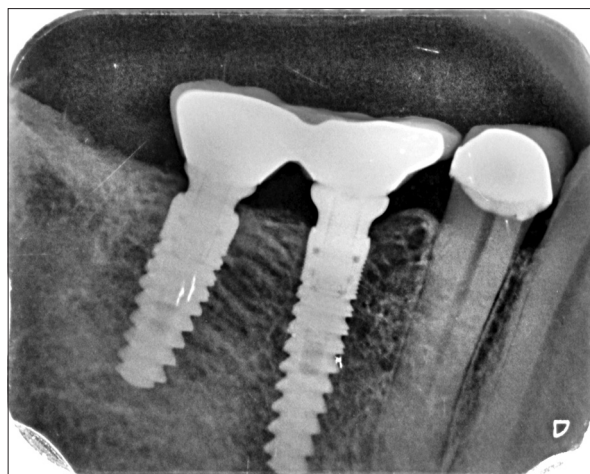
The digital intraoral periapical image of Case no 5, 6 months after prosthesis that is 1-year postimplant insertion showing good osseointegration and maintained cervical bone level
